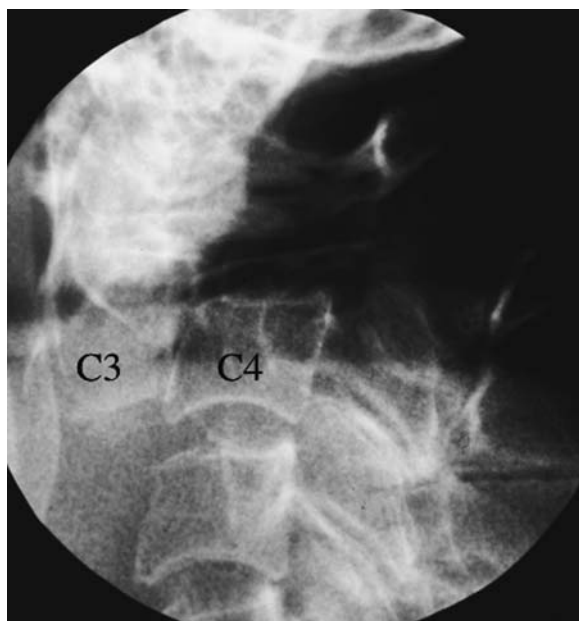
Cervical distraction injury. Lateral view radiograph
